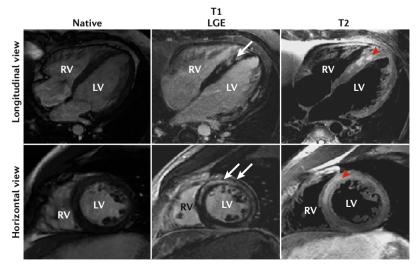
Cardiac MRI. Cardiac MRI of patients with endomyocardial-biopsy-proven active myocarditis shows evidence of late gadolinium enhancement (LGE) (white arrows), indicating fibrosis and oedema (red arrowheads). LV, left ventricle; RV, right ventricle.
